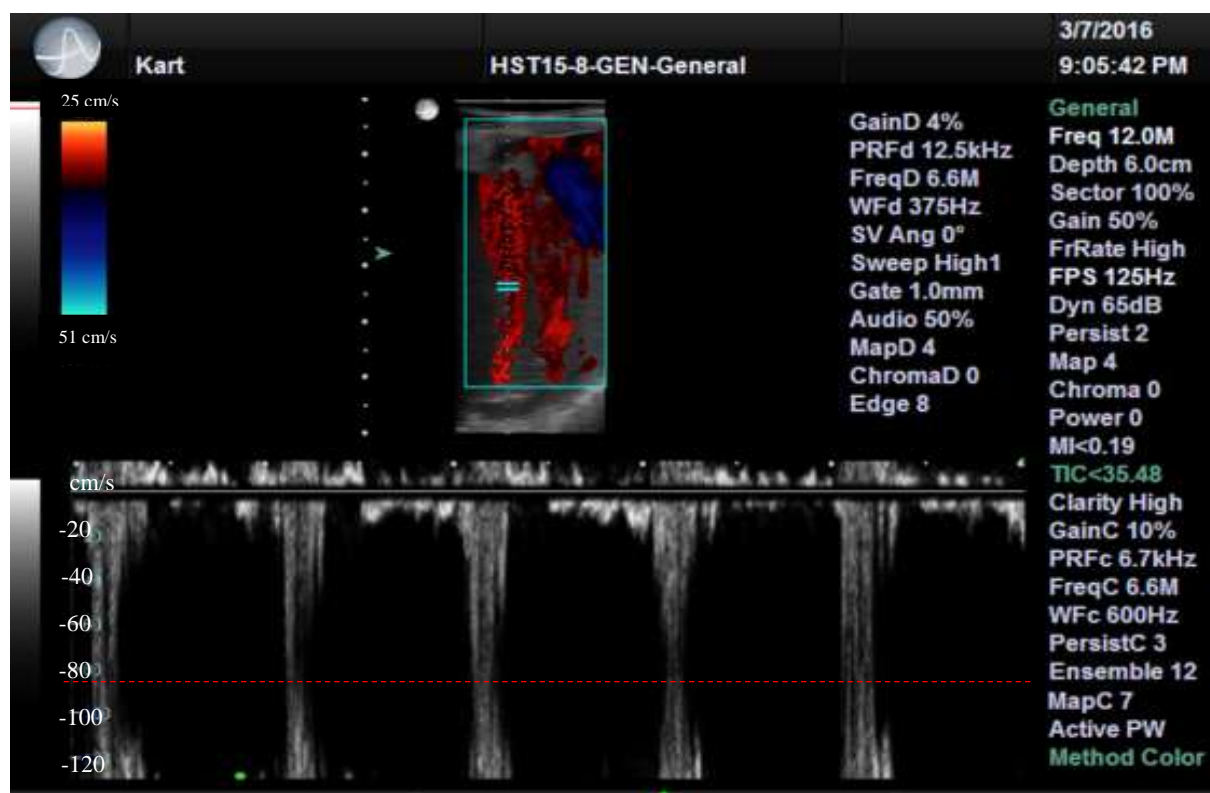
Doppler echocardiography to determine the maximum velocity in (A) the regurgitant model and (B)
